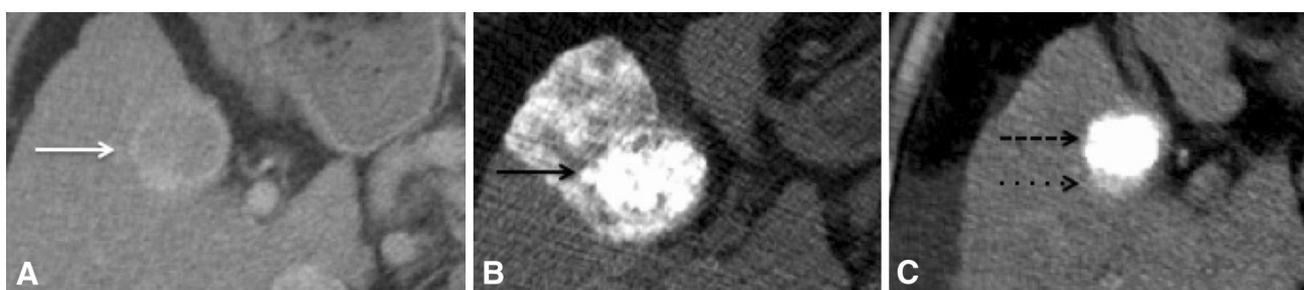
A 62-year-old male with a 3.6-cm HCC (white arrow). The patient received monotherapy with TACE. B Immediate post-embolization CT demonstrates diffuse Lipiodol uptake by the tumor (black arrow), which was completely covered.
